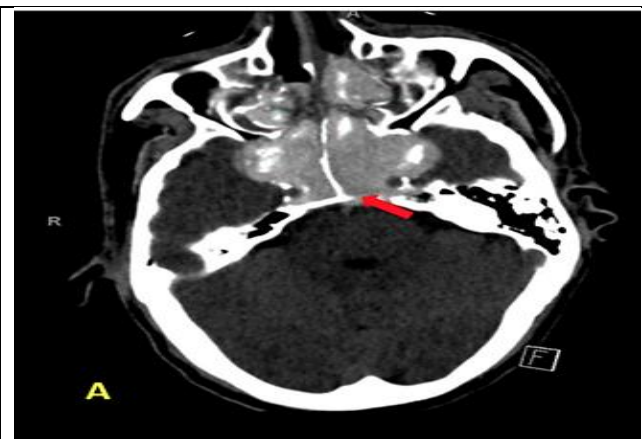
The unenhanced axial CT brain showing maxillary antra with sinus wall destruction and infiltration into the bilateral cavernous sinus and pre-pontine cistern, as well as complete hyper-attenuating soft tissue opacification of the enlarged sphenoid and ethmoid sinuses. A red arrow on a dense basilar artery indicates thrombosis.
